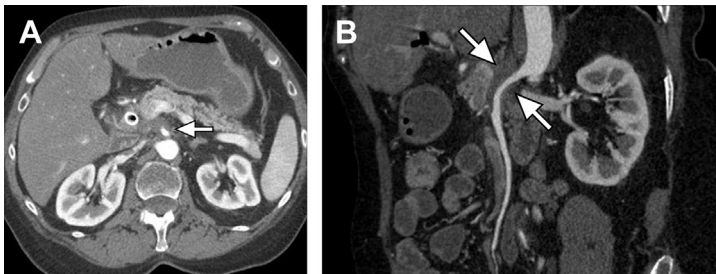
Superior mesenteric artery (SMA) tumor contact. (A) Axial contrast-enhanced multi-detector computed tomography (MDCT) image through the pancreatic head demonstrate an ill-defined mass surrounding the SMA (arrow) surrounding more than 180° of the vessel circumference. (B) Curved reformatted image through the SMA displays the entire length of the vessel and confirms the circumferential contact between the tumor and the vessel (arrows) and the mild narrowing in the vessel caliber.
